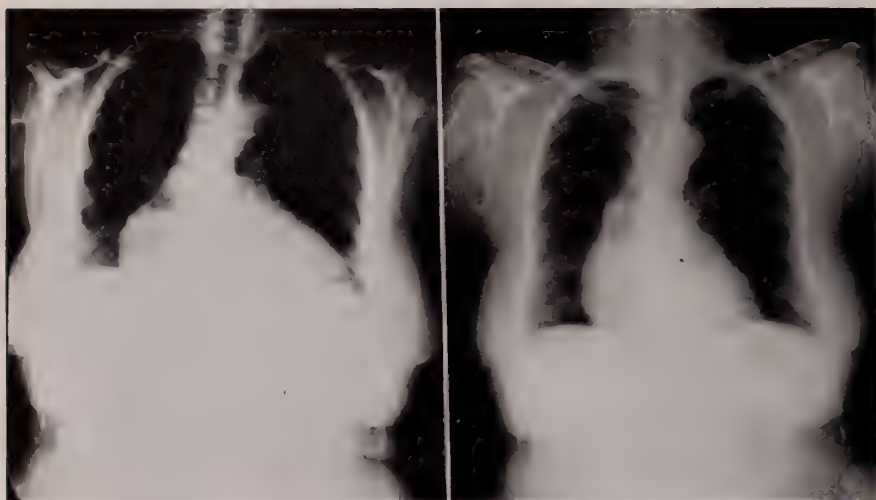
Chest x-ray taken on the fifth hospital day demonstrating an enlarged cardiac silhouette, with an appearance suggesting fluid in the pericardial space.
